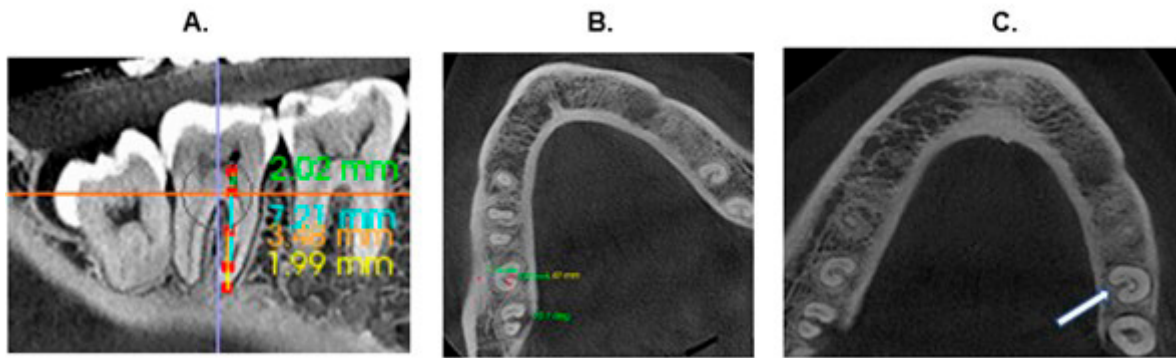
A. Sagittal view of the CBCT exemplifying the three levels at which the evaluation was performed: coronal, middle and apical. B. Cross section in the middle third for type II and III classification analysis according to Fan *et al.* 2004. C. Cross section in the middle third for analysis of the presence of the groove (arrow).
